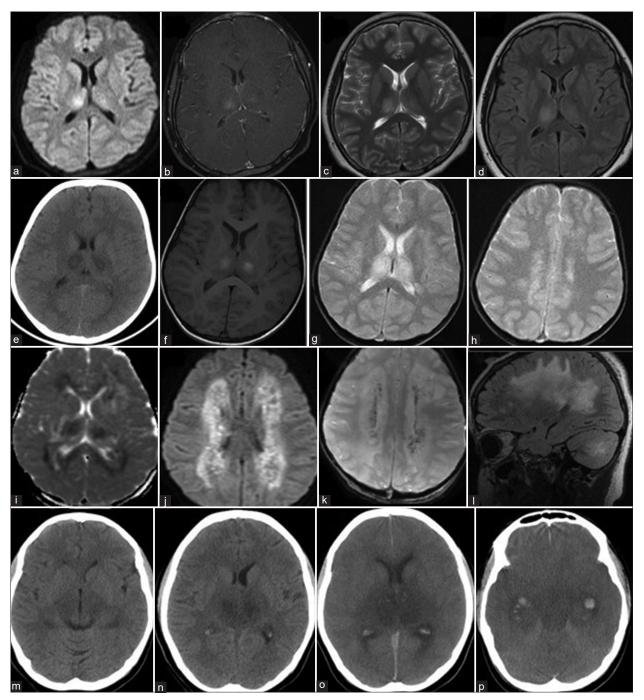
(a) Axial diffusion-weighted image shows restricted diffusion in bilateral thalami. (b) Axial T1 post-contrast image shows enhancement in thalami R>L. (c and d) Axial T2-weighted and T2 fluid-attenuated inversion recovery images show hyperintensities in bilateral thalami from a child with good recovery without any deficits. (e) Axial image of non-contrast computed tomography head shows bilateral thalamic hypodensities. (f) Axial T1-weighted image shows thalamic hyperintensities. (g and h) Axial gradient echo image shows hyperintensities in bilateral thalami and deep white matter in a child with mild to moderate disability-learning disability, squint, epilepsy. (i) Axial apparent diffusion coefficient maps suggest restricted diffusion in bilateral thalami and periventricular white matter. (j) Axial diffusion-weighted restricted diffusion in bilateral deep white matter. (k) Axial susceptibility-weighted images suggest haemorrhage in the central part of bilateral deep white matter lesions. (l) Sagittal T2-weighted image shows hyperintensities in cerebral and cerebellar white matter from a child with severe disability-wheel chair bound. (m and n) Axial non-contrast computed tomography (CT) head shows hypodensities in midbrain, subthalamic nucleus and bilateral thalami at admission. (o and p) Axial non-contrast CT head a day later shows hypodensities in thalami with effacement of sulcal spaces, blurring of grey-white junction and intraventricular bleed in a child who succumbed to acute necrotising encephalopathy of childhood.
